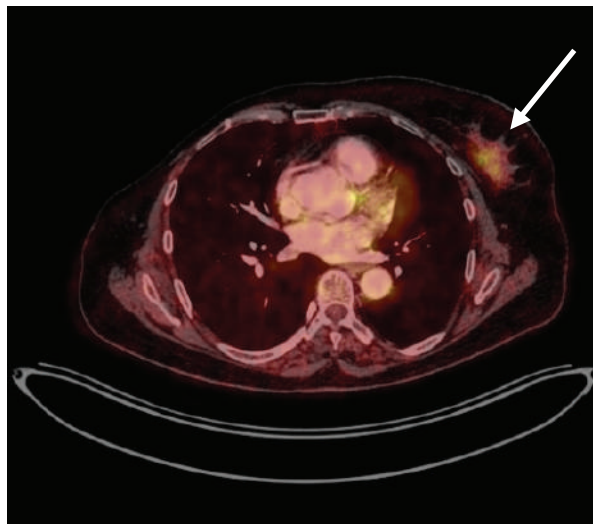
PET-CT image of a 43-year-old woman with right breast carcinoma, following surgery, showed a heterogeneously enhancing FDG avid (SUVmax: 4.2), lobulated, soft tissue density, and an outer margin mass lesion (3.6 X 2.6 X 1.8 cm) possibly due to disease recurrence.
